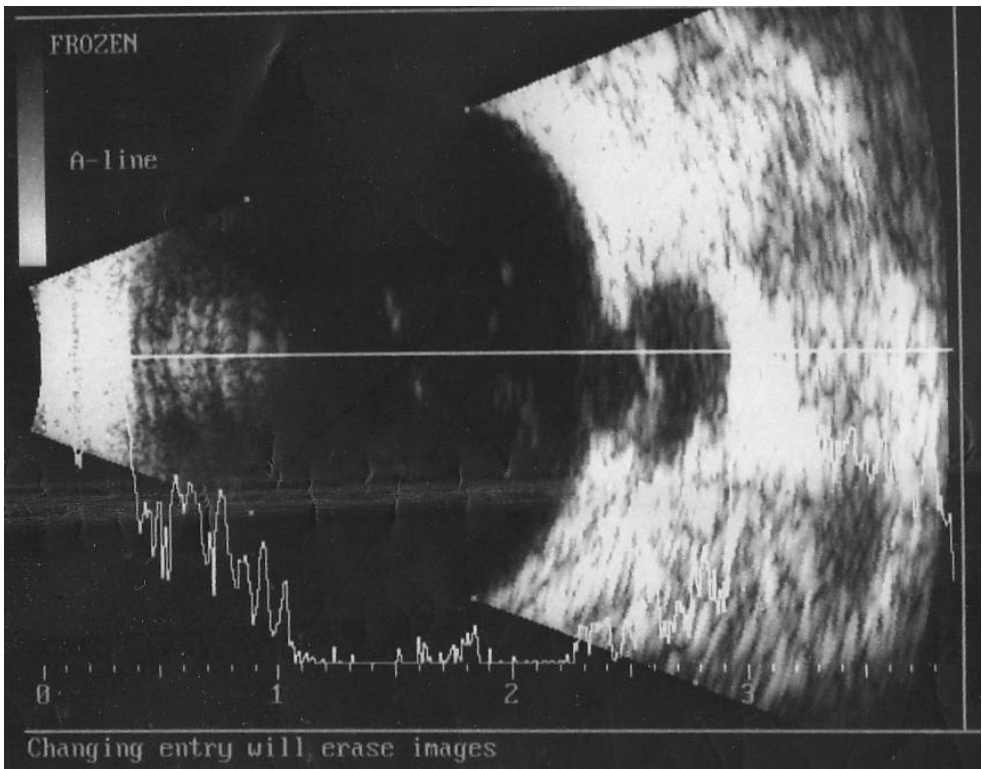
Ultrasound examination of the right eye.
